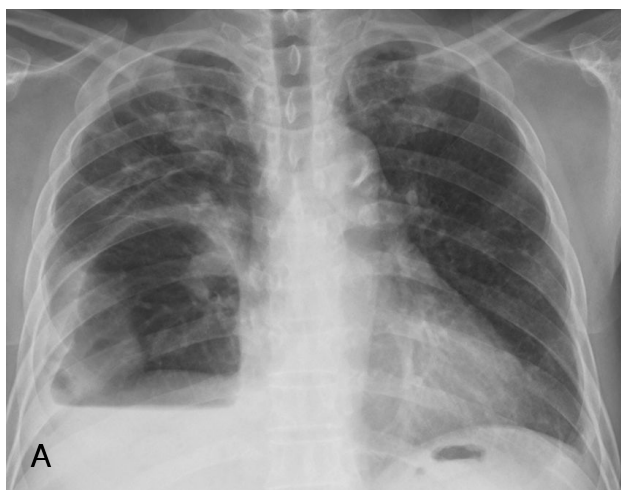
On the ninth day of hospitalization, (A) Chest radiography showed the increased size of the air-cyst and air fluid level in the right lower lung. (B) Enhanced chest CT scan showed a 9×11 cm sized, thin-walled cavitory lesion, with an air-fluid level, pleural effusion and consolidation in the right lower lung.
